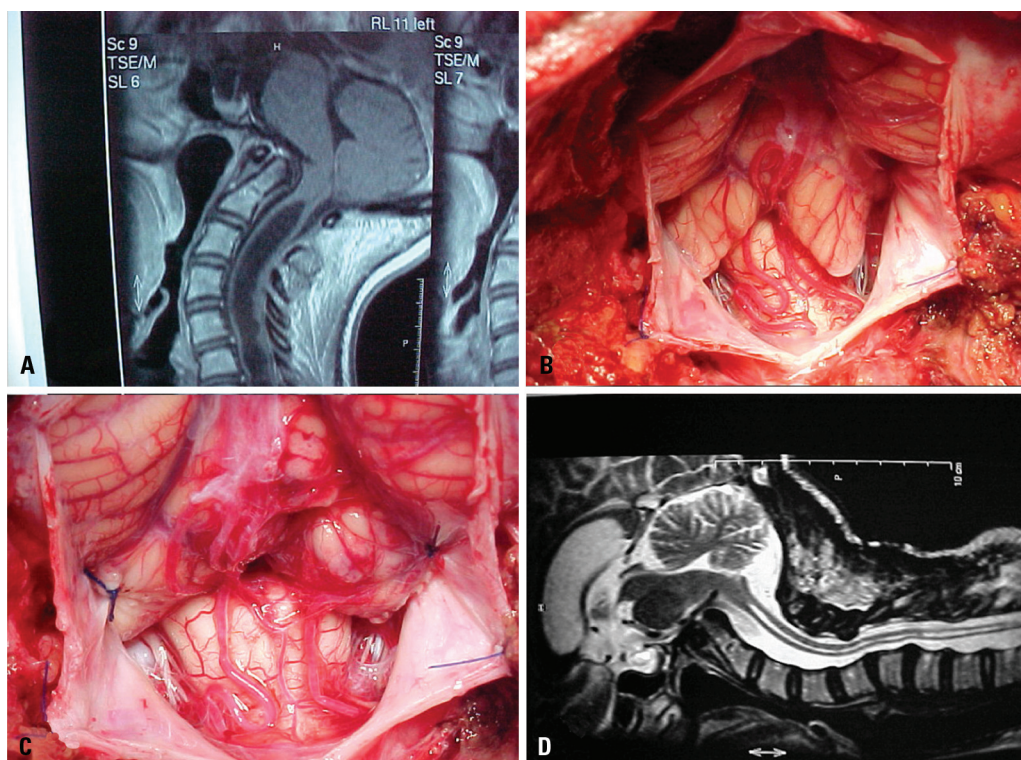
[A] Preoperative MRI demonstrating syringomyelia without tonsillar herniation. [B] Herniation of the cerebellar tonsils with the patient in sitting position. [C] Tonsilectomy and large opening of the fourth ventricle. [D] Postoperative MRI showing dramatic reduction of the syringomyelic cavity.
